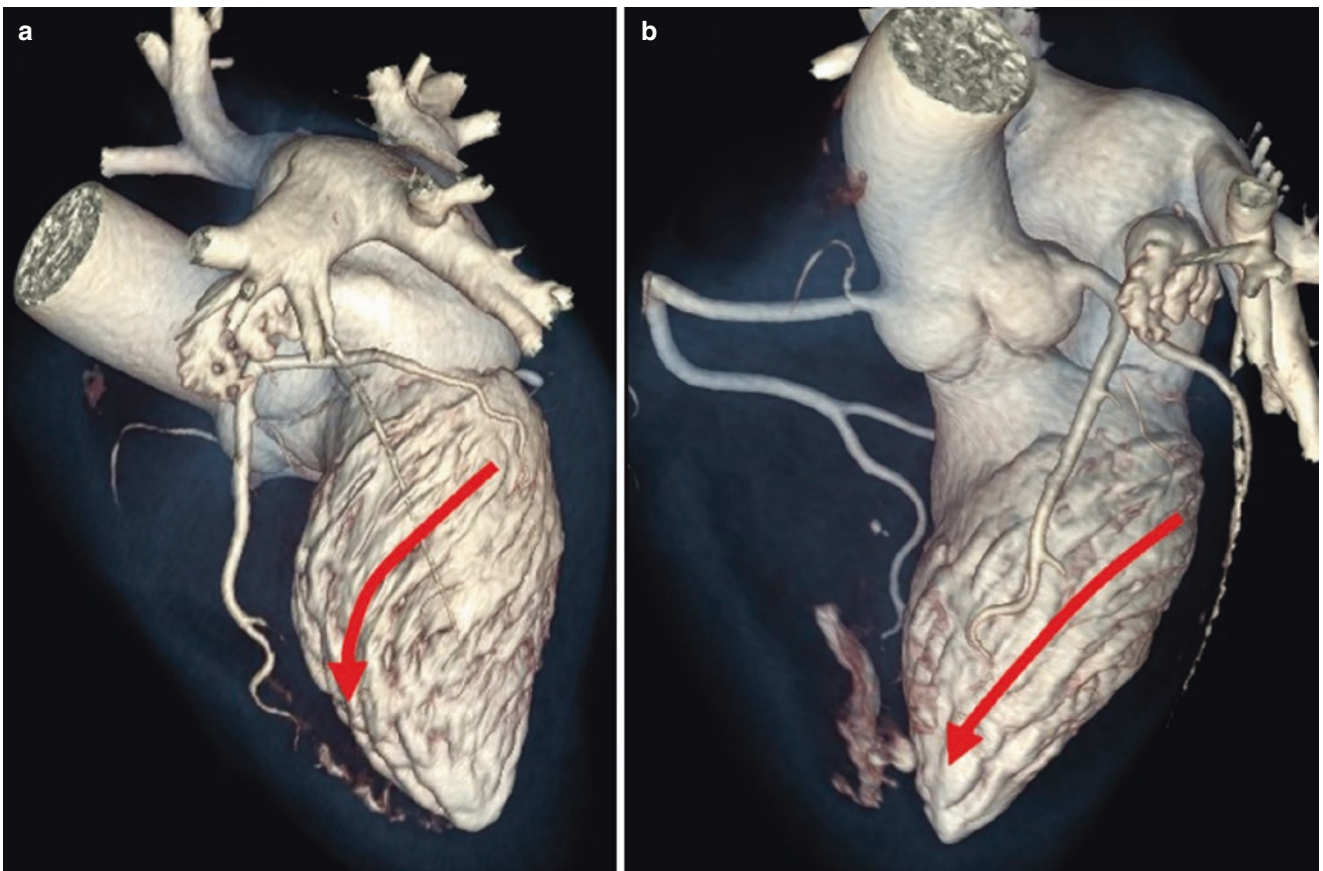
(a and b) Electronic cast obtained by CT scan making transparent the myocardium and opaque the contrast into the LV cavity. These casts show a helical arrangement of trabeculations (*curved red arrows*)
